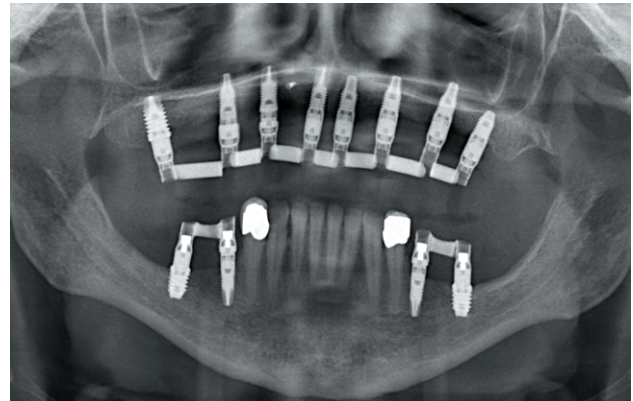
X-Ray image of the patient with the second progressive loading prosthesis.
